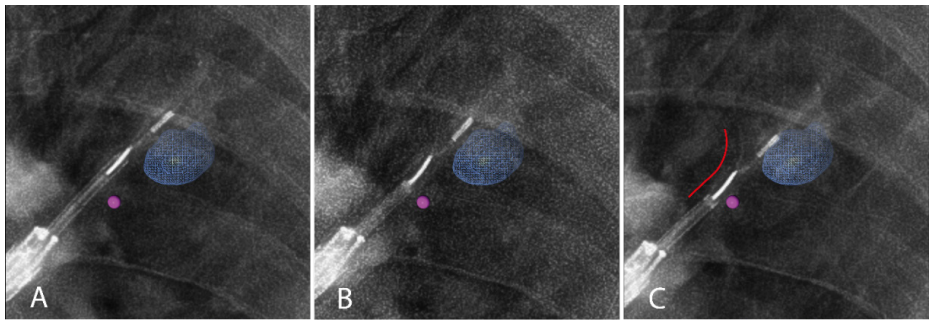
Visualization of the Pioneer Plus catheter near the lesion on AF with the needle in sheath (A), the needle deployed (B) and the catheter moved more distal to push the needle further into the tissue to enhance angulation (C). The needle sheath and US-transducer appear to be radiopaque, whilst the needle is (minimally) radiopaque. A peritumoral injection was performed here. A red line is added for reference of the needle position. AF, augmented fluoroscopy; US, ultrasound.
